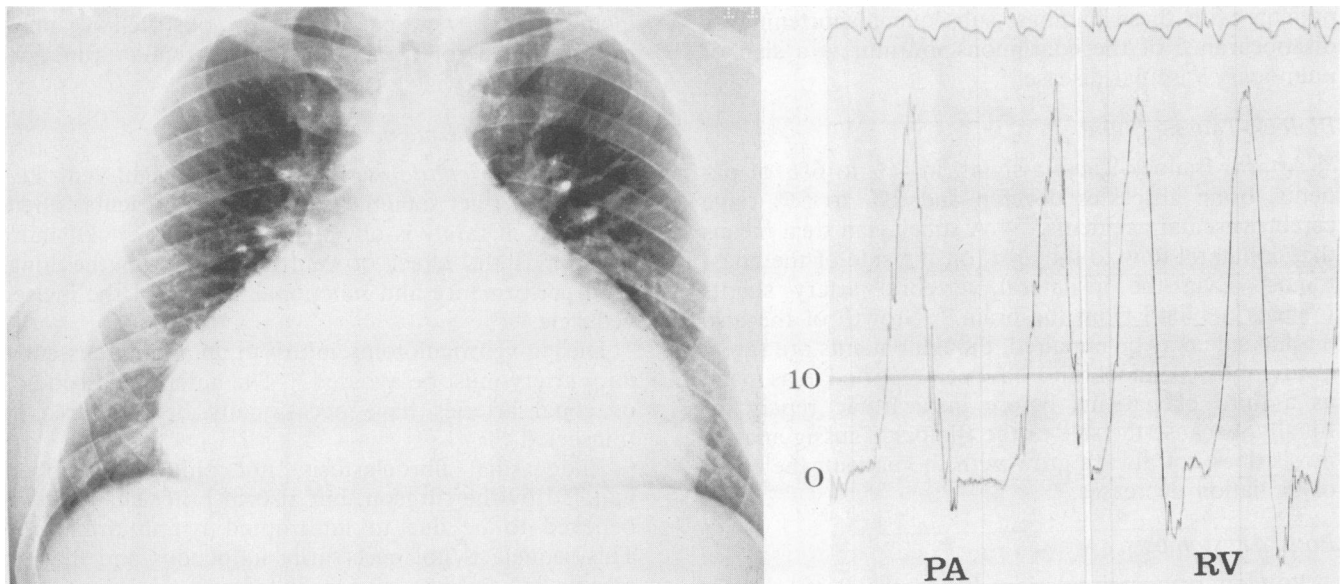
Chest roentgenogram (A) and right heart pressure pulses (B) in a 30-year-old man who at 10 years of age underwent primary intracardiac repair for tetralogy of Fallot. Twenty years after operation severe pulmonary regurgitation culminated in right ventricular failure, tricuspid regurgitation and atrial flutter. The chest x-ray study shows massive cardiomegaly due to right atrial and right ventricular dilatation. The pulmonary arterial (PA) and right ventricular (RV) pressure pulses show no obstruction, identical diastolic pressures (free pulmonary regurgitation) and an early diastolic dip in the RV.
